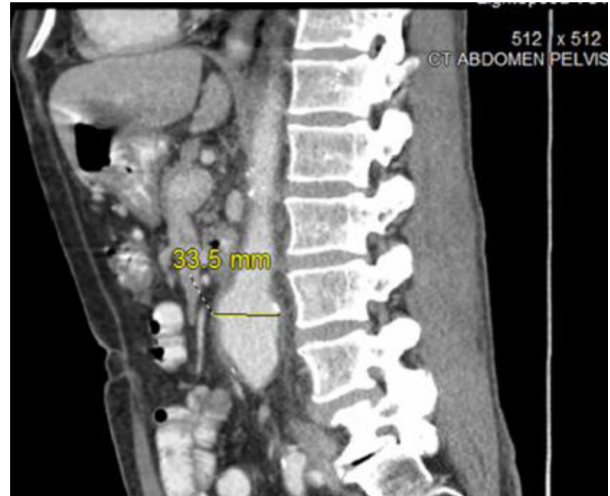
CT angiogram of abdomen and pelvis – sagittal section showing the mycotic aneurysm.
